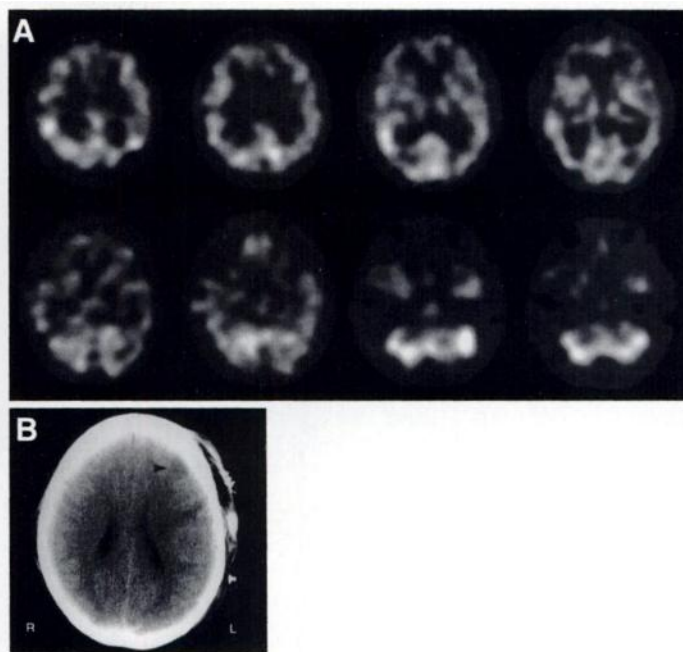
A 25-yr-old woman with rhabdomyosarcoma in the right infra-temporal fossa. The occlusion study shows symmetric perfusion in both hemispheres (A). CT scan performed 1 wk after ICA ligation (B) shows an infarct in the left frontal watershed area (arrow). The patient remained asymptomatic.
